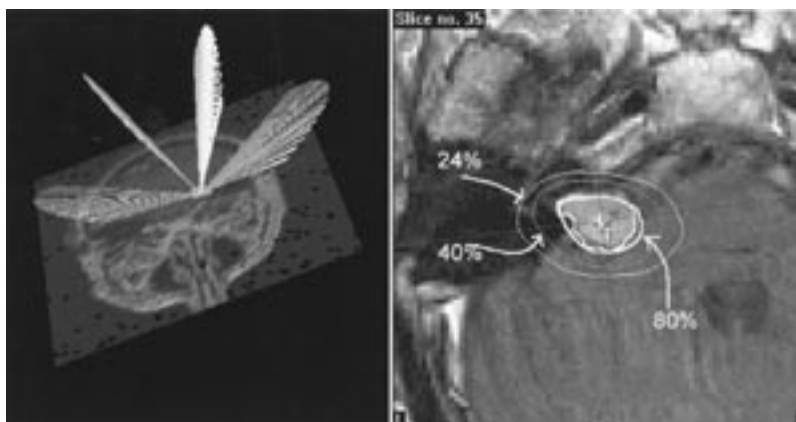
Magnetic resonance imaging reconstructed image of the radiosurgical plan for a small acoustic neuroma. The arrows point to isodose lines. These lines enclose areas receiving a percentage of the maximum radiation delivered to the target. The 100% is usually a point in space. For this reason, the treatment dose is prescribed to a lesser isodose line, which encloses the tumor well. The tumor is treated with a single isocenter with beams produced by a mini-multileaf collimator and the dynamic conformal arcs technique. Conformality to the target is excellent.
